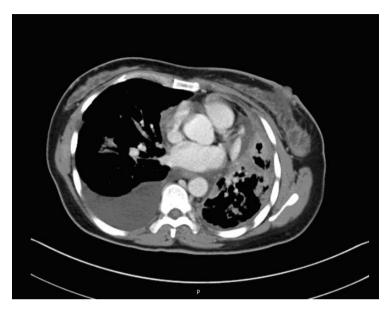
CT coronal view showing the left upper lung mass with associated consolidation of the left lower lobe and left side pleural effusion.
